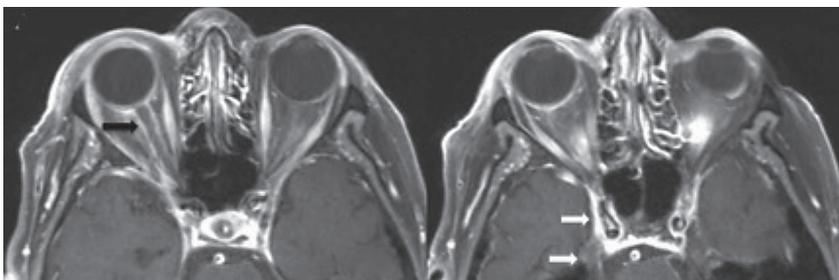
Axial post-contrast, fat suppressed T1-weighted MRI images showing the right optic sheath enhancement (black arrow) with orbital apex involvement (white arrow); asymmetric enhancement in the right superior orbital fissure extending along the right cavernous sinus, right Meckel's cave and cisternal segment of the right trigeminal nerve.
